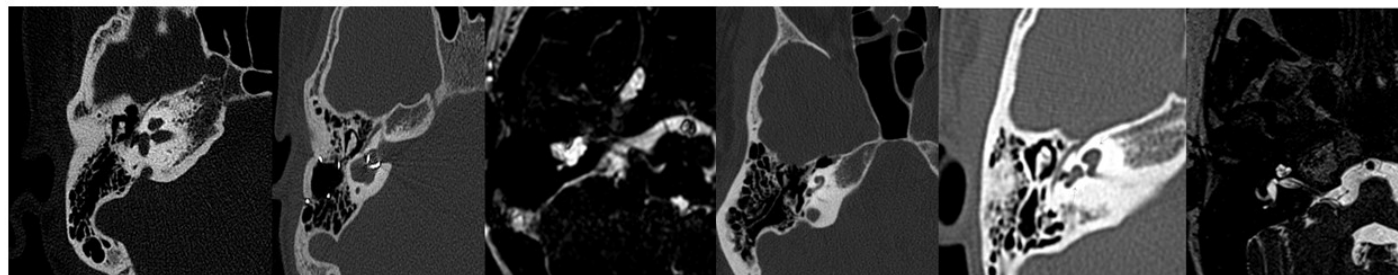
Axial HRCT of the temporal bone of same patient demonstrates cystic fusion of the apical and middle cochlear turns (arrowheads), with absent modiolus and interscalar septum at the apex, and an enlarged right vestibular aqueduct (arrow). The normal interscalar septum indentation in the medial cochlea is absent.
